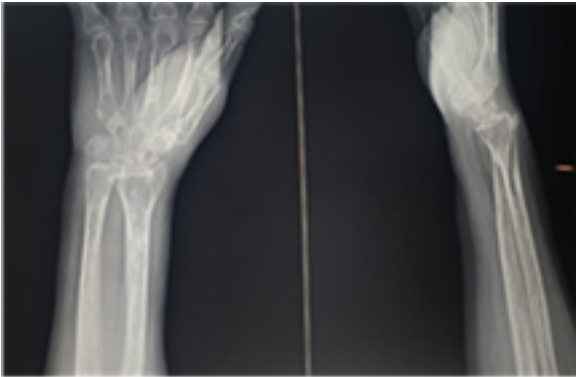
Pre-Op x-ray: Malunited colles fracture with positive ulnar variance
